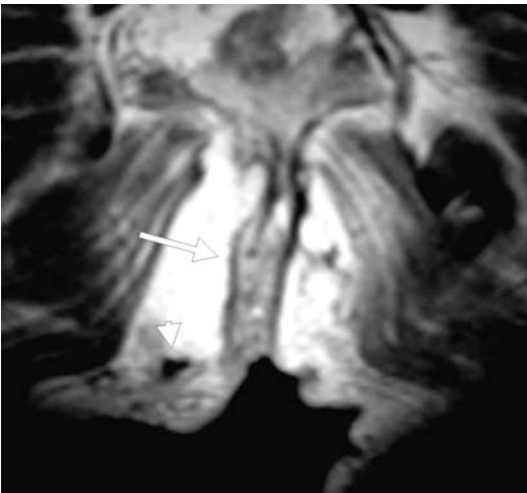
Coronal T1-weighted MR image after contrast enhancement shows a right-sided intersphincteric fistula (*arrow*) entering the anal canal in the midline posteriorly and an abscess in the right ischioanal fossa (*arrowhead*).
